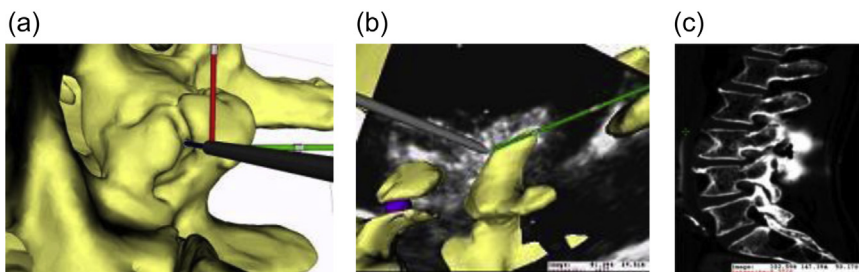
(a) Accurate placement of the needle tip in the facet joint, (b) real-time ultrasound is used to confirm needle placement, and (c) confirmation by radiopaque injectant in the X-ray image.
